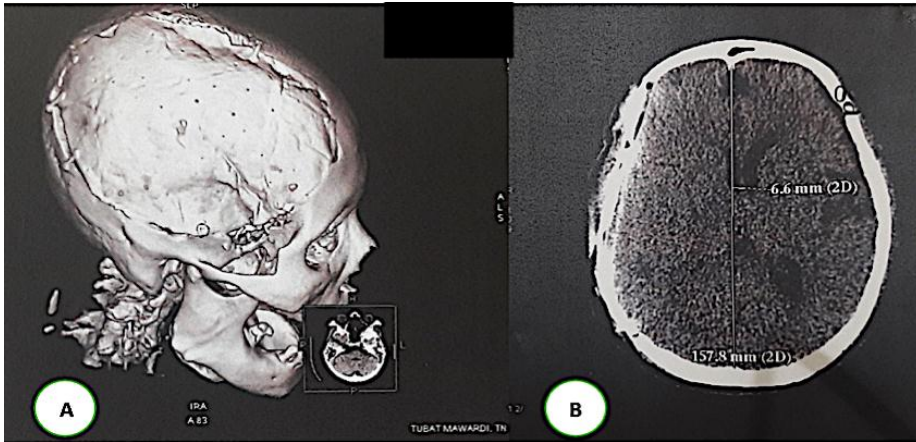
CT Scan Patient Evaluation. (A) 3D Reconstruction Pieces; (B) Axial cut.
